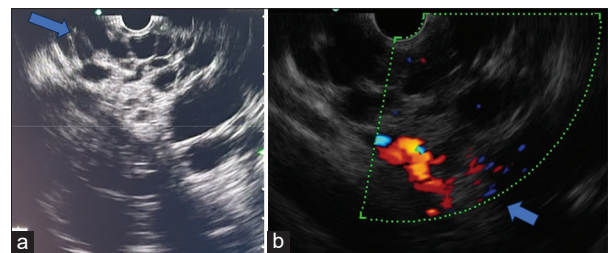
(a) Endoscopic ultrasound showing multiple variable-sized cysts in pancreas (arrow), (b) On color Doppler there is no flow in cysts (arrow)
